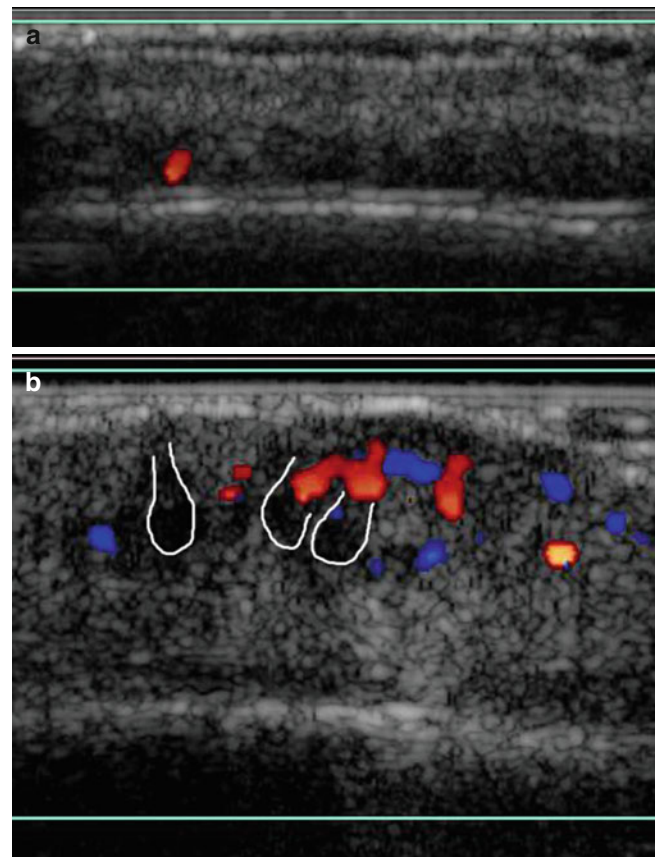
(a, b) Color Doppler sonographic image showing grading of vascularity of the scalp. (a) Normal. (b) Increased (hair follicles outlined)
